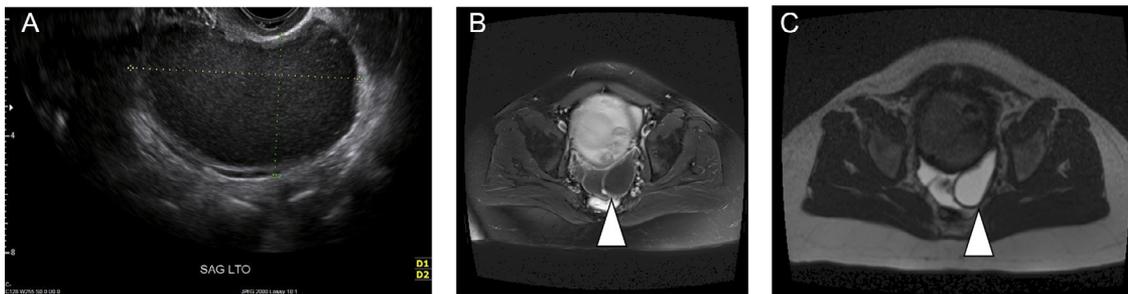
Cystic ovarian tumors. (A) Unilocular cystic tumor with compact internal echoes and a thick wall. (B) Axial T1-weighted postcontrast image demonstrates an enhancing wall. (C) T1-weighted axial image demonstrates a cystic mass (arrowhead) with high signal internal contents and a low signal intensity rim characteristic of an endometrioma. The diagnosis of an endometrioma was confirmed at surgery performed because of the patient's symptoms.
